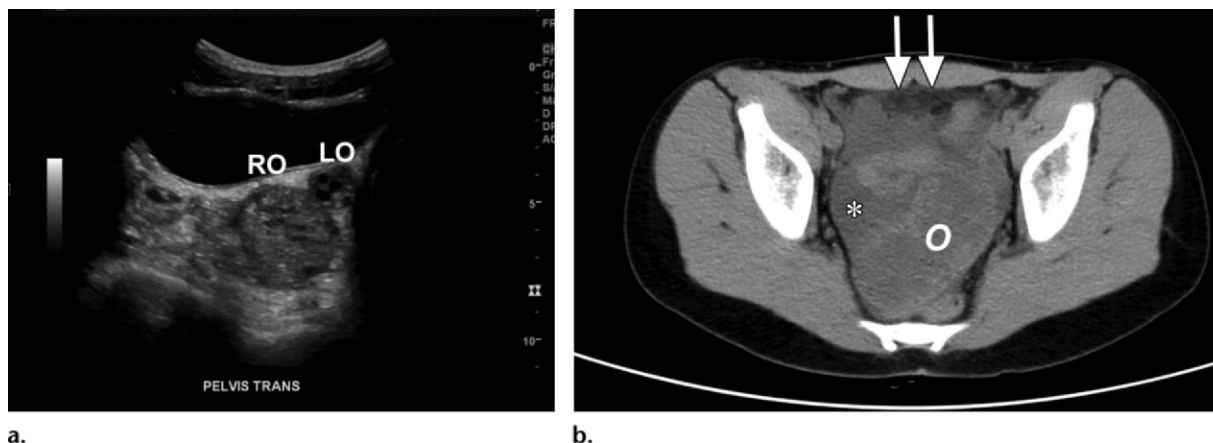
Ovarian torsion in a 14-year-old girl. (a) Transverse gray-scale US image shows an enlarged, predominantly solid-appearing torsed right ovary (RO) in the midline posterior to the bladder. Physiologic follicles are seen in the normal small left ovary (LO). The volume of the right ovary is 25 times greater than that of the left ovary. The surgically proven diagnosis was ovarian torsion. (b) Axial non-contrast material-enhanced computed tomographic (CT) image of the pelvis shows a midline to left-sided mass (O) with predominantly central low attenuation, consistent with a torsed right ovary. Free fluid (*) and increased attenuation of the anterior pelvic fat (arrows) also are seen.
